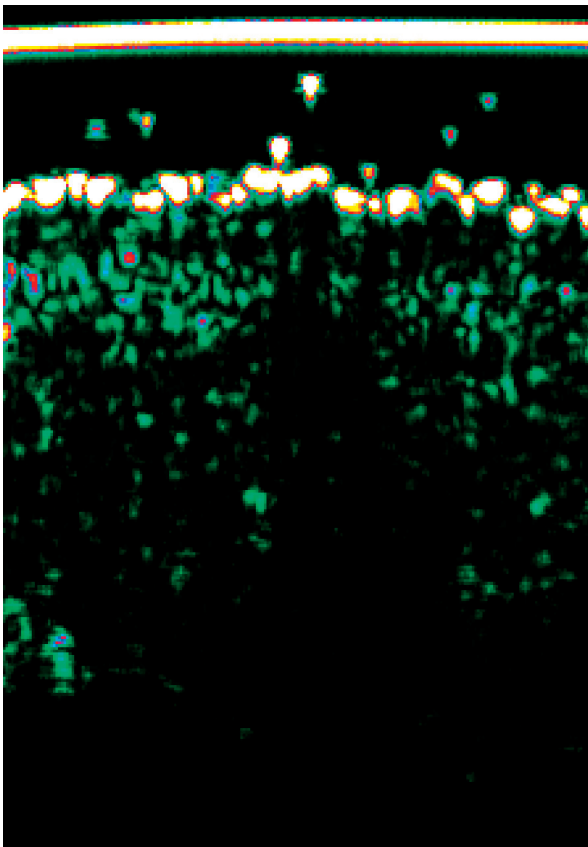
Ultrasound scan before UVA1 irradiation
